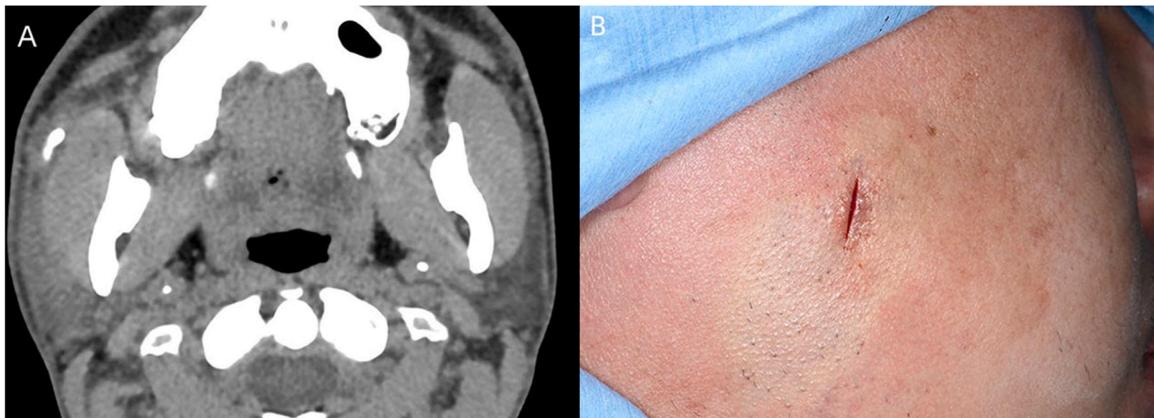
The case of a 28-year-old man with an impacted stone of the right parotid gland. Axial computed tomography showed a 10-mm stone in the middle third of the duct. (B) The stone was removed via a 12-mm vertical incision.
